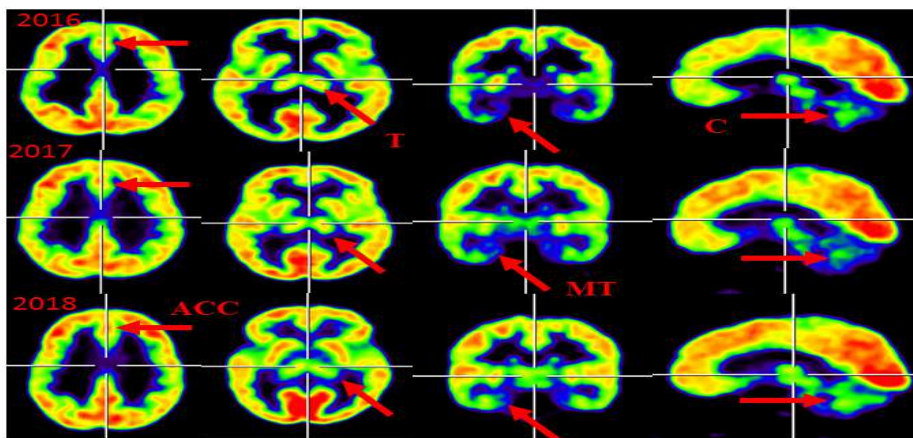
Representation of Axial, coronal and sagittal slice of ^{18}F -FDG-PET image of the patient with DS. (Top row) PET image before stem cell therapy, (Middle row) PET image after one year following cell therapy and (Bottom row) PET image after twenty months of stem cell therapy, showing improved brain activity in bilateral Anterior cingulate cortex (ACC), Medial temporal cortex (MT) and Cerebellum (C) as compared with the previous PET image. The arrow head indicates the regions of interest.
